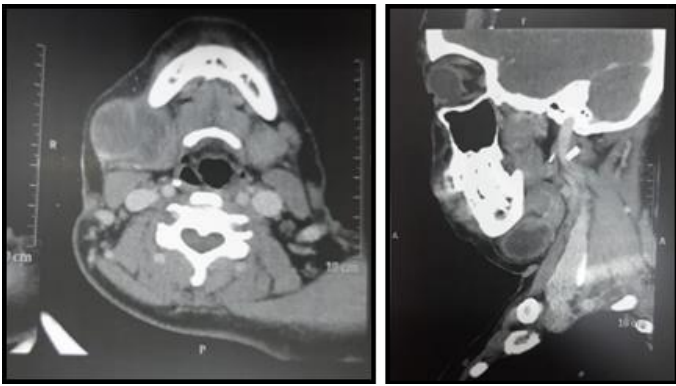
(A, B): CT scan (Axial and lateral view) showing cystic lesion with an irregular wall at right side Level IB, showing central area of necrosis
